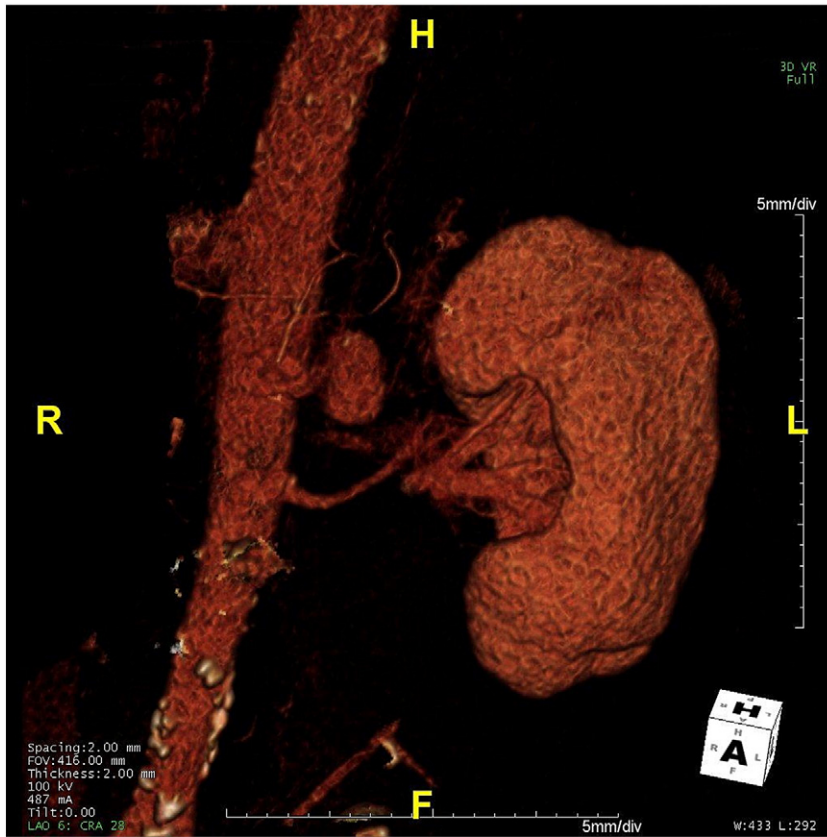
CT angiogram with 3D reconstruction demonstrating the splenic arterial aneurysm.
